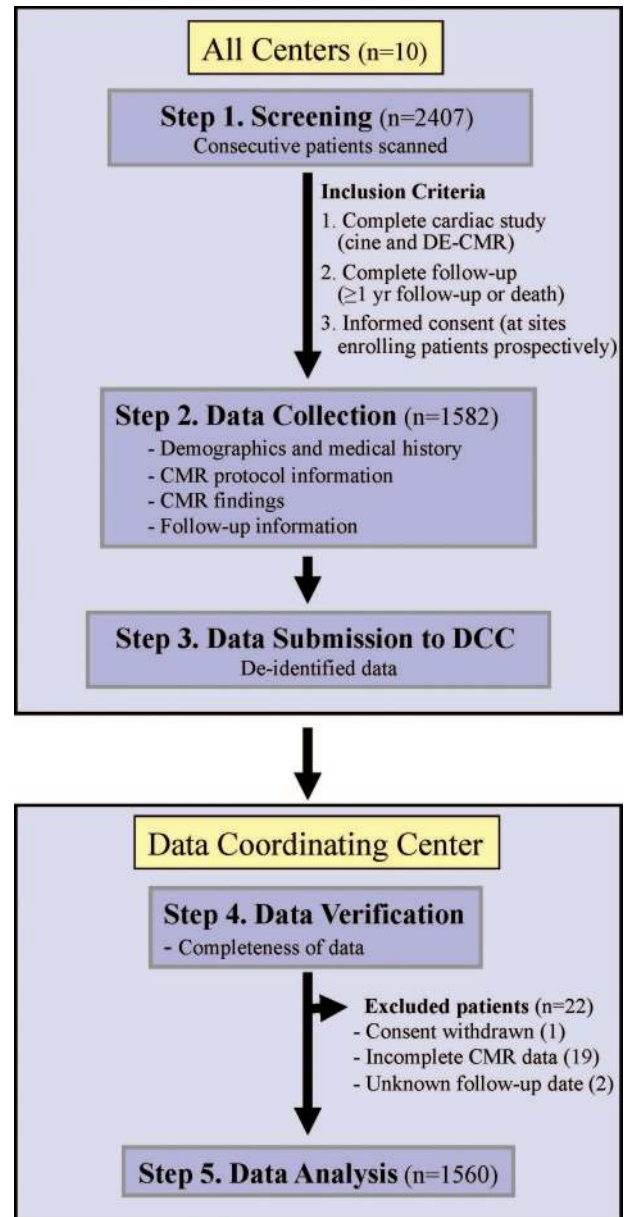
Outline of patient enrollment and data collection. The first 3 steps occurred at the individual participating centers and involved patient screening, data collection from enrolled patients, and data submission after deidentification. Steps 4 and 5 included data verification and analysis at the DCC. At each cardiovascular MRI center, consecutive patients of either gender undergoing an MRI (either cardiac, vascular, or both) were screened. All patients screened were subsequently enrolled unless they had only a vascular study (no cardiac imaging), had an incomplete cardiac study (eg, cine imaging without DE-CMR), did not have a full year of follow-up, or did not give informed consent (at sites enrolling patients prospectively). After submission of enrolled patient data to the DCC, 22 patients were excluded because of withdrawal of consent (n=1), incomplete CMR protocol information or CMR findings (n=19), or incomplete follow-up data (n=2). CMR indicates cardiac magnetic resonance; DCC, data coordinating center; DE, delayed enhancement.
